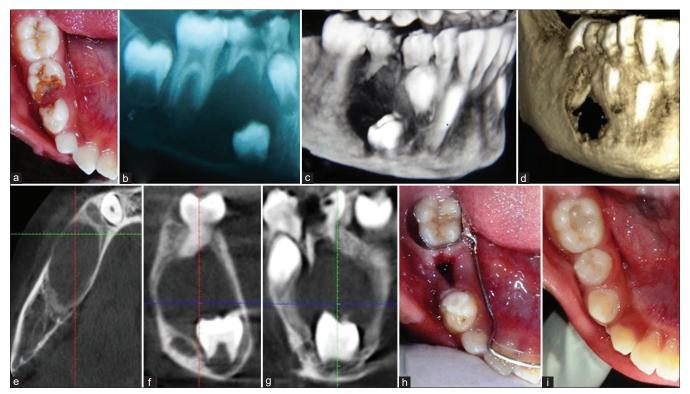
(a) Lower right occlusal view; (b) orthopantomograph (lower right side); (c) computerized tomography scan (lower right anterior view); (e) computerized tomography scan (lower right occlusal view); (f and g) computerized tomography scan cross-sectional view; (h and i) lower right occlusal view
